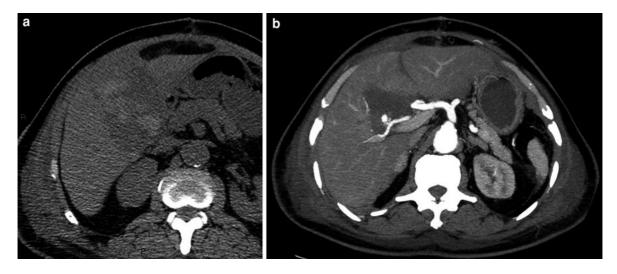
CT scan after laparoscopic cholecystectomy. a areas of higher attenuation on unenhanced CT in the gallbladder bed. b CT during the arterial phase demonstrating a pseudoaneurism of the cystic artery
